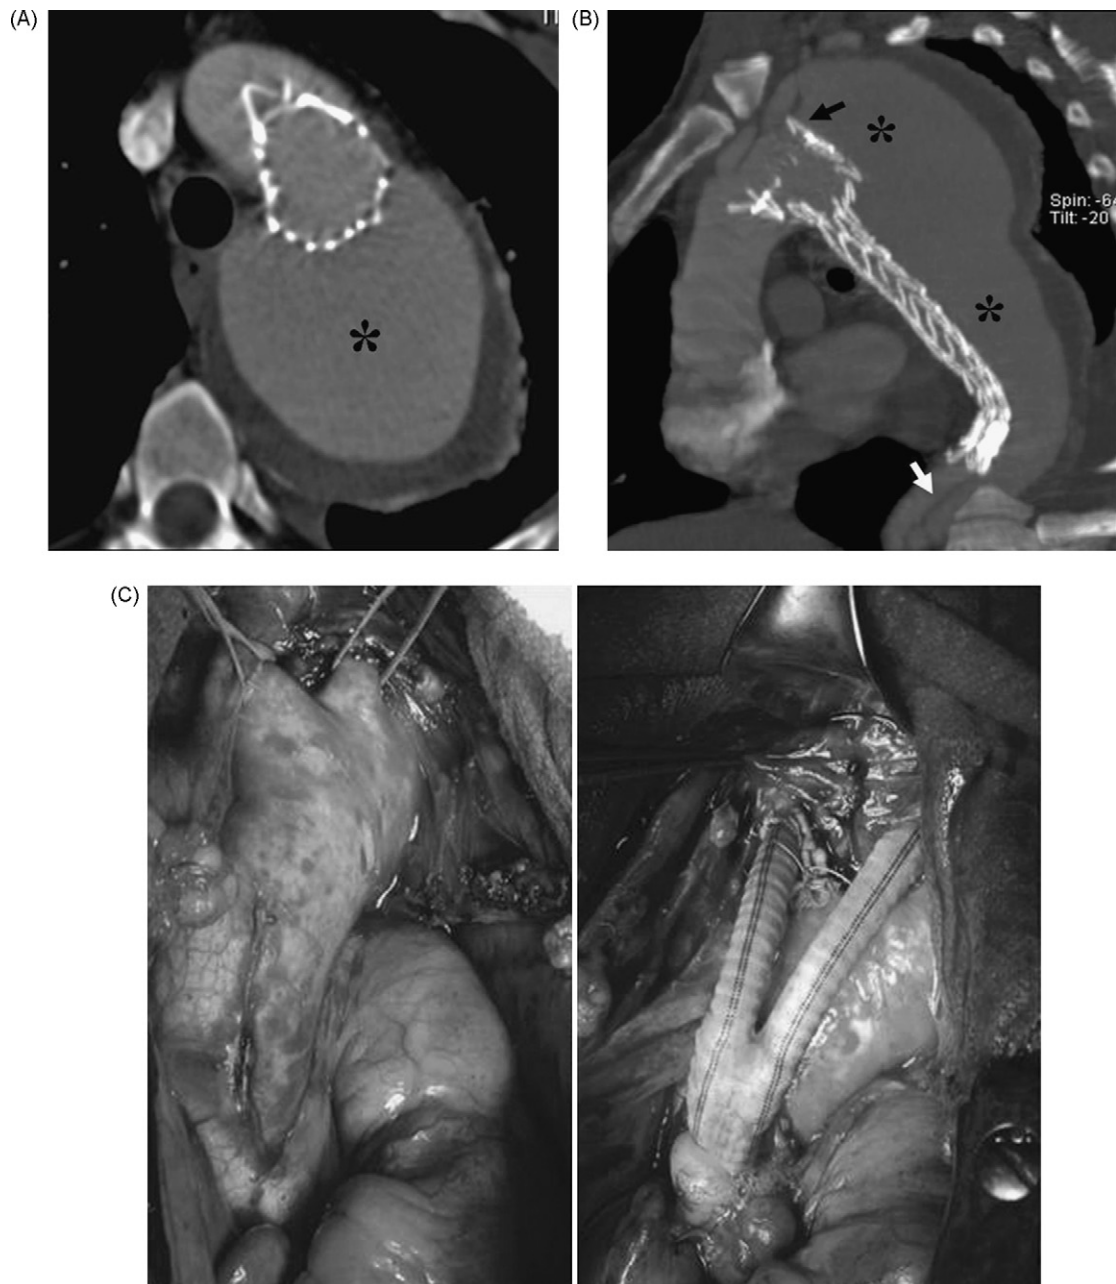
A 41-year-old man underwent endovascular graft of the descending thoracic aorta for treatment of a post-type-B dissection false lumen aneurysm with concomitant collapsed true lumen. Due to lack of a proximal neck (intimal flap was extended from the ostium of subclavian artery), covered proximal boundary of endovascular graft was placed just below the ostium of left carotid artery, covering the left subclavian artery ostium. (A and B) Follow-up CT images show a caudal migration of the stent-graft (arrow in B) with concomitant reperfusion of the aneurysmatic false lumen (proximal type-I endoleak) (asterisks). (B) MIP-image also depicts partial true lumen/stent-graft collapse. On the basis of CT-findings, aortic cuff was deployed in the ascending aorta with debranching of the arch by performing an ascending aorta–carotid/innominate artery bypass (C). (D and E) MIP and (F) CPR images, performed 6-months after re-intervention, show patency of the ascending aorta and surgical bypass (arrows in D and E), with re-expansion of the true lumen/stent-graft and complete exclusion by flow of the false lumen (asterisk in D). Reduction in size of the false lumen is also depicted.
